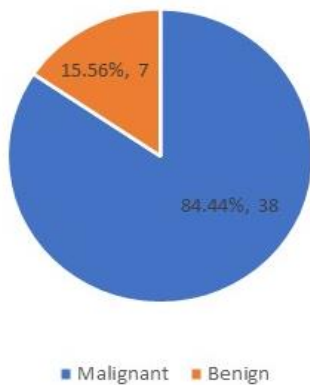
Distribution of patients by diagnosis of gallbladder mass using CT scans (N=45)
